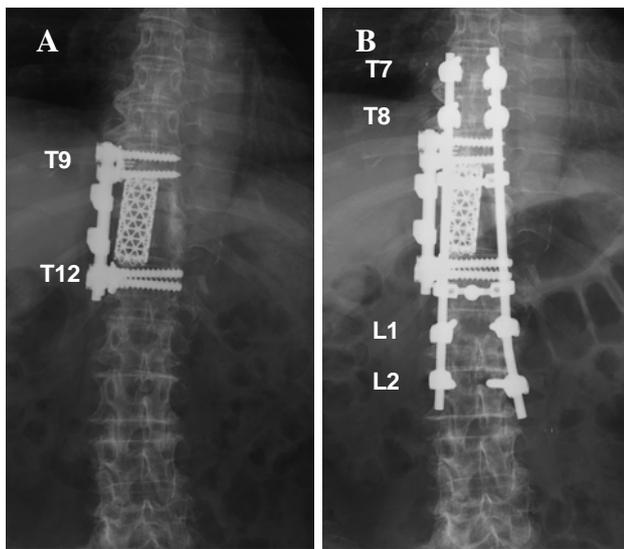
Antero-posterior view of radiographs of the thoraco-lumbar spine taken after the second (A) and third (B) operation. A) Radiograph taken after anterior corpectomy and fusion. Vertebral bodies of T10 and T11 are replaced by a titanium mesh cage. Four titanium screws in the vertebral bodies of T9 and T12 are linked by longitudinal rods. B) Radiograph taken after posterior fixation. Pedicle screws are placed bilaterally in T7, T8, L1, and L2. Pedicle screws are linked by longitudinal rods.
